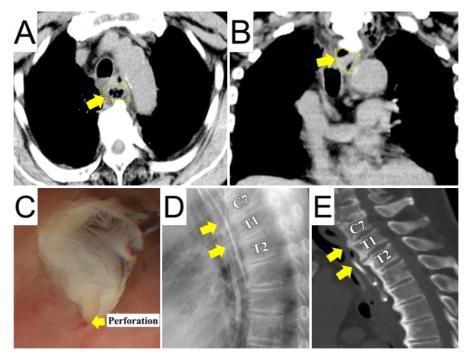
Chest computed tomography (CT), gastrointestinal endoscopy, and esophagography.
